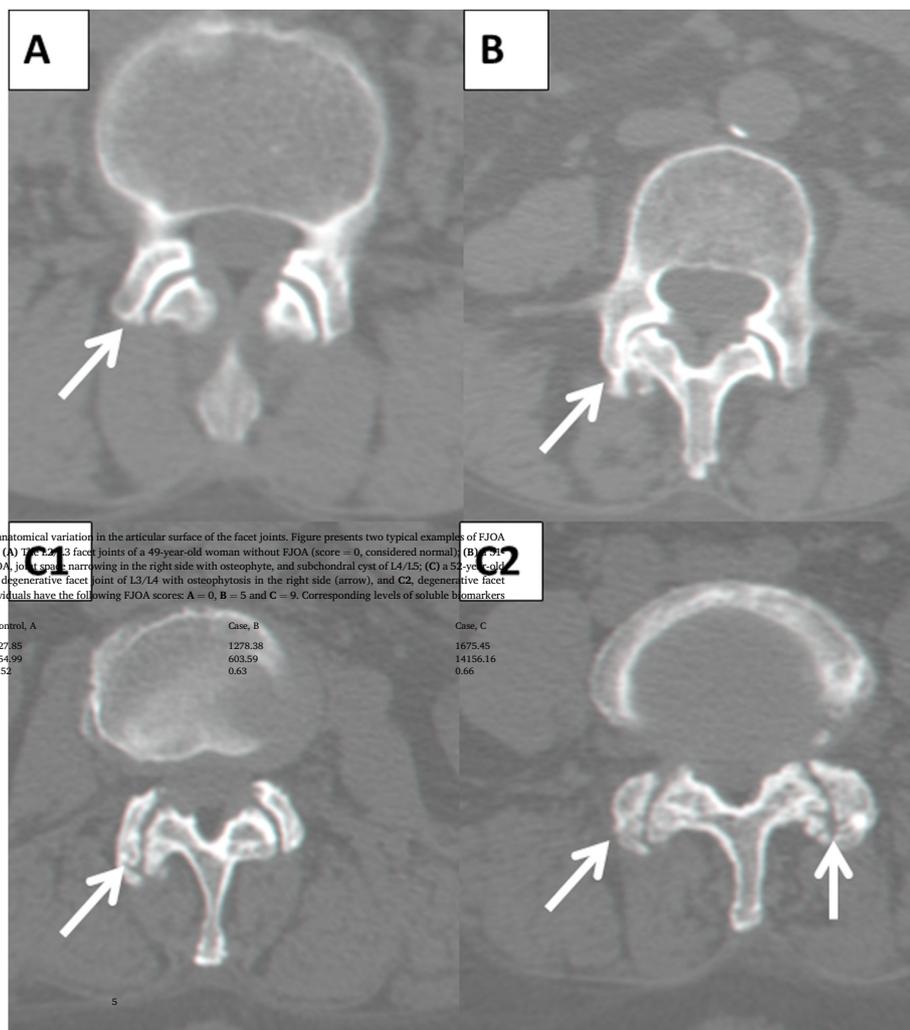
Axial computed tomography images depicting the anatomical variations in the articular surface of the facet joints. Figure presents two typical examples of FJOA appearance in two LBP individuals vs a healthy individual. (A) The L4/L5 facet joints of a 49-year-old woman without FJOA (score = 0, considered normal); (B) 51-year-old woman with LBP accompanied by sciatica and FJOA, focal space narrowing in the right side with osteophyte, and subchondral cyst of L4/L5; (C) 52-year-old woman with LBP accompanied by sciatica and FJOA: C1, degenerative facet joint of L3/L4 with osteophytosis in the right side (arrow), and C2, degenerative facet joint of L4-5 with the osteophytosis in both sides. The individuals have the following FJOA scores: A = 0, B = 5 and C = 9. Corresponding levels of soluble biomarkers and ECW are presented in the table.
